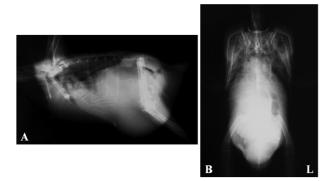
Radiographs of an Amazon parrot with hepatic fibrosis and hepatitis. A: Right lateral view. This radiograph shows marked hepatomegaly with cranial displacement of the heart, dorsal displacement of the proventriculus, and caudodorsal displacement of ventriculus. B: Ventro-dorsal view. This radiograph shows a widening of the hepatic silhouette and a loss of the cardio-hepatic waist.
